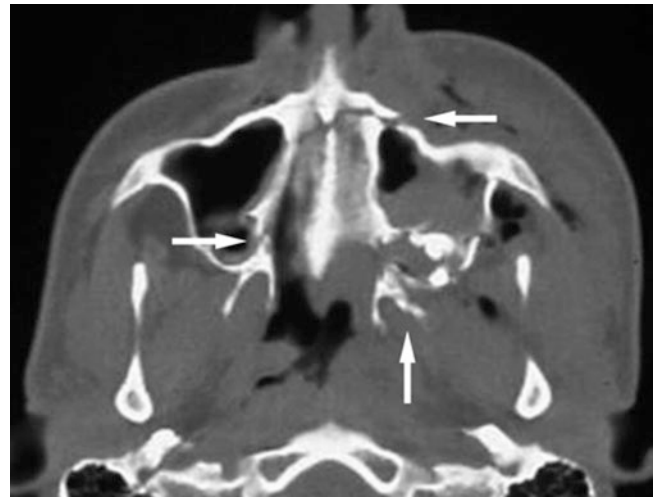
LeFort 2 fracture with a zygomatic arch nondisplaced fracture; 37-year-old male who was assaulted. (A) Axial CT image shows bilateral fractures of the anterior part of the maxilla (*arrow*), lateral-posterior part of the maxilla (*arrow*), and pterygoid plates (*arrow*). Hemorrhage in maxillary sinuses and multiple air collections. (B) Axial
